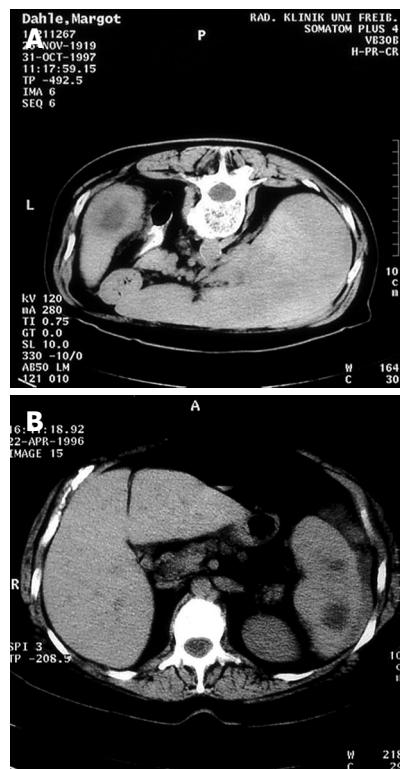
A: CT scan of a 50-year-old woman. The spleen contained a single abscess of 3 cm \times 3 cm; B: CT scan of a 40-year-old male sailor, which featured multiple splenic abscesses.
